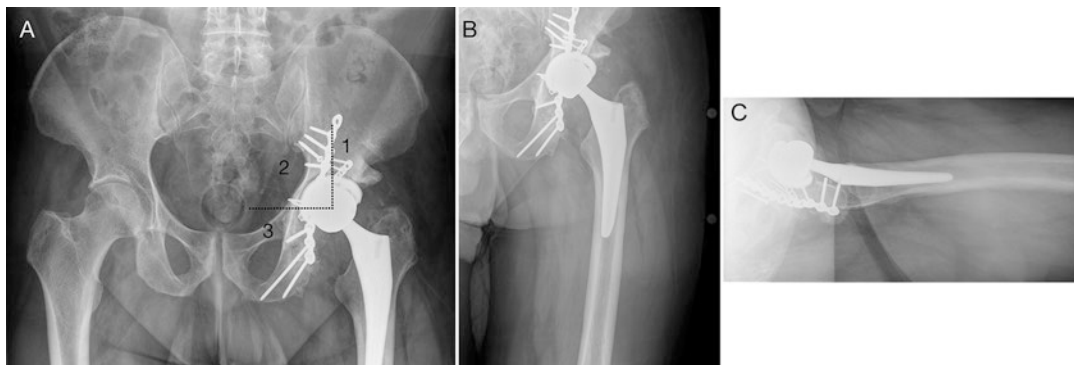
Presenting radiographs of a 56-year-old male patient who presented with left hip pain following a THA that was performed for post-traumatic arthritis at an outside institution. Anteroposterior (AP) view of the pelvis (a), AP radiograph of the left hip (b), and cross-table lateral view of the left hip (c) demonstrate a radiolucent line surrounding the entire circumference of the cup in all
